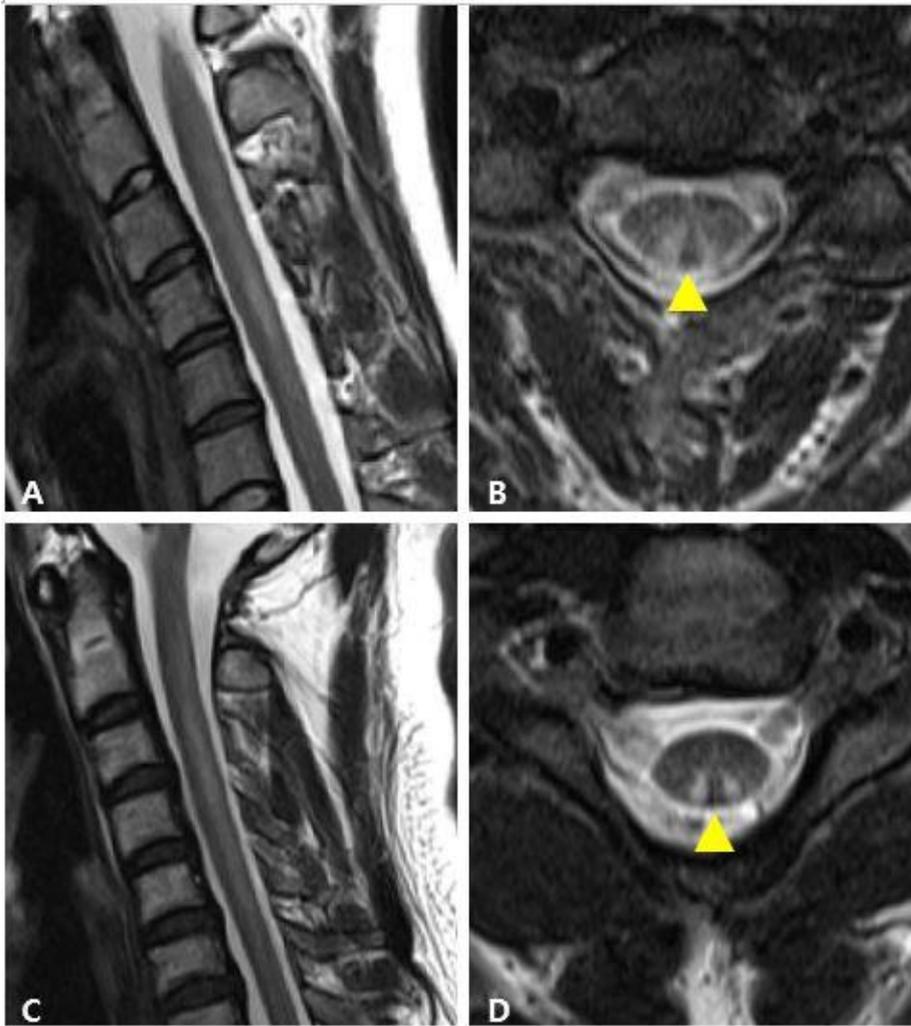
T2 weighted images of cervical MRI.
